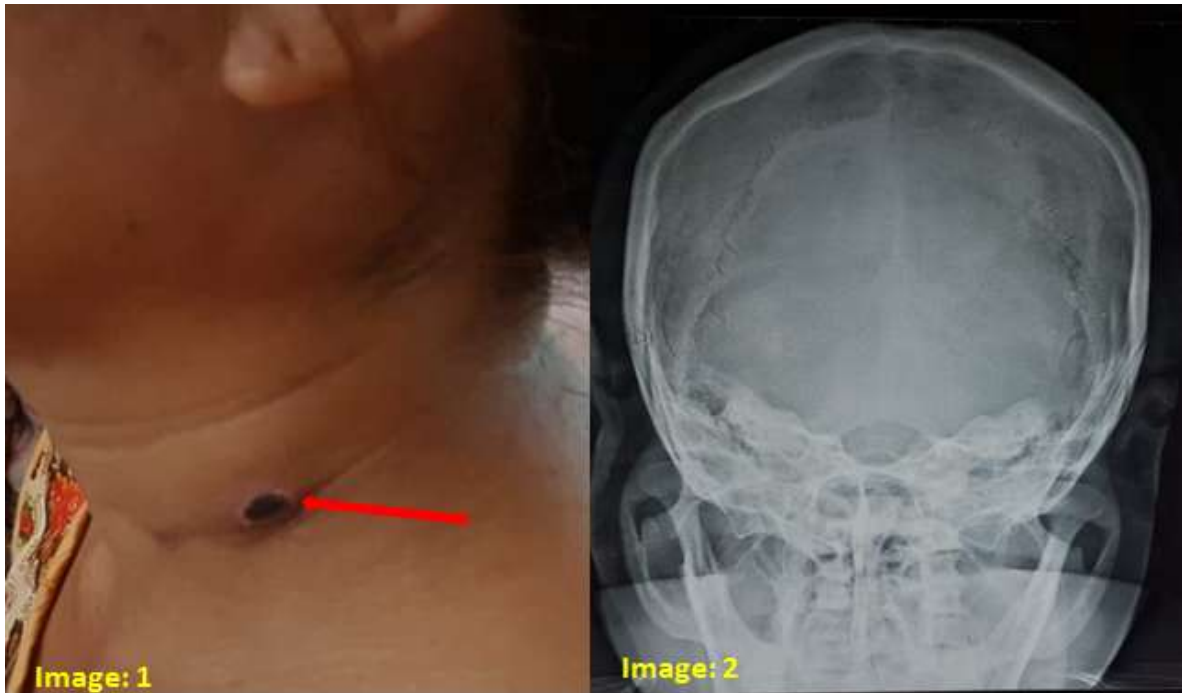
characteristic flat black eschar in nape of the neck. Image 2: HRCT scan of the temporal bone showing opacity and fluid in bilateral mastoid air cells.
